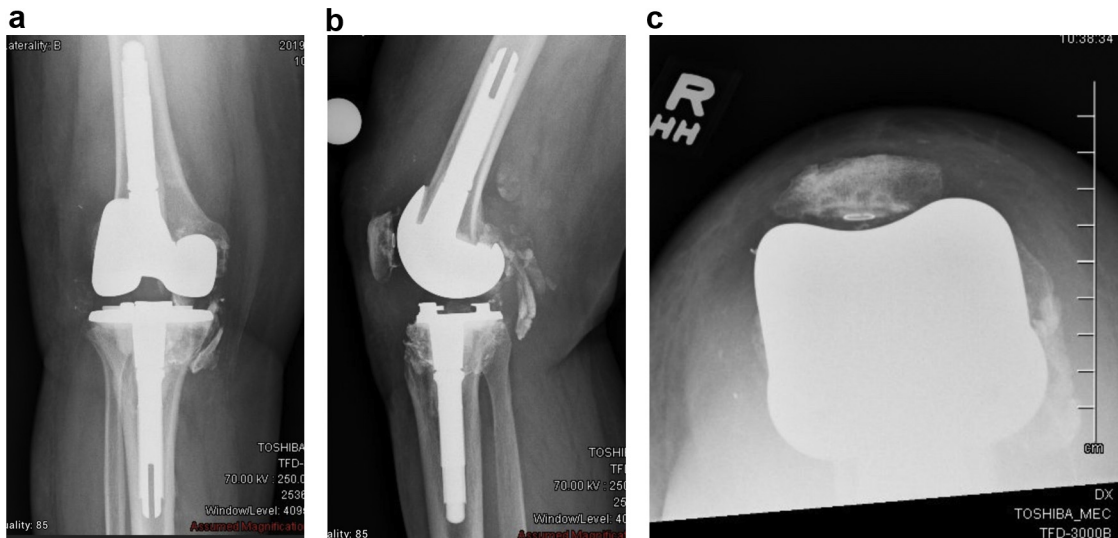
Postoperative anteroposterior (a), lateral (b), and sunrise (c) radiographs after synovectomy and revision to a stemmed, constrained condylar TKA.
